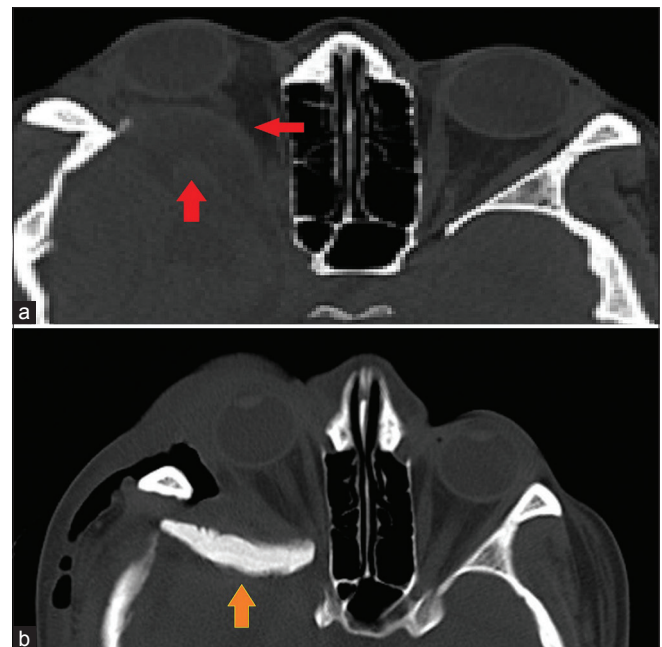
Axial computed tomography scan images in the bone window (a) preoperative computed tomography shows right eye proptosis with herniation of temporal lobe compressing optic nerve. (b) Immediate postoperative computed tomography showing reduced herniation with polymethyl methacrylate graft *in situ* with soft-tissue edema
